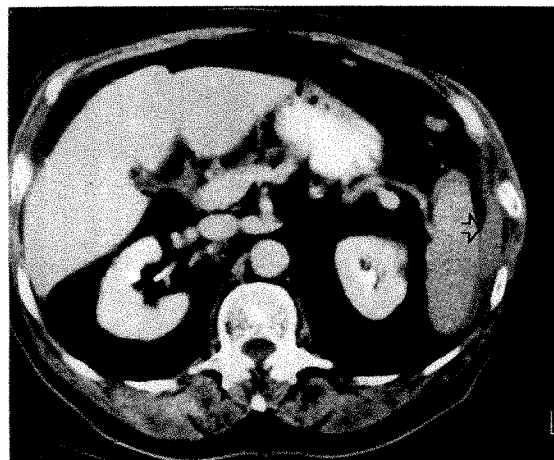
Surgically confirmed splenic laceration. CT scan shows focal hyperdense clot (arrow) adjacent to spleen. No parenchymal lesion is evident.
